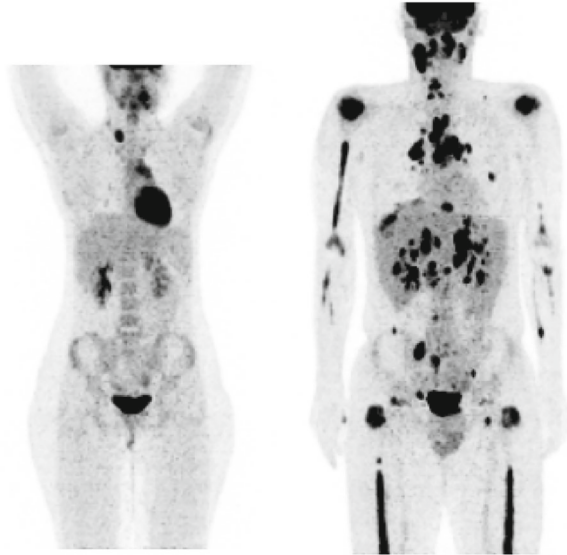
^{18}F -FDG PET/CT for the staging of Hodgkin Lymphoma patients. 2D sagittal images: (left) tumor at stage II; (right) tumor at stage IV. (Courtesy of Paola Erba, University of Pisa, 2014)
